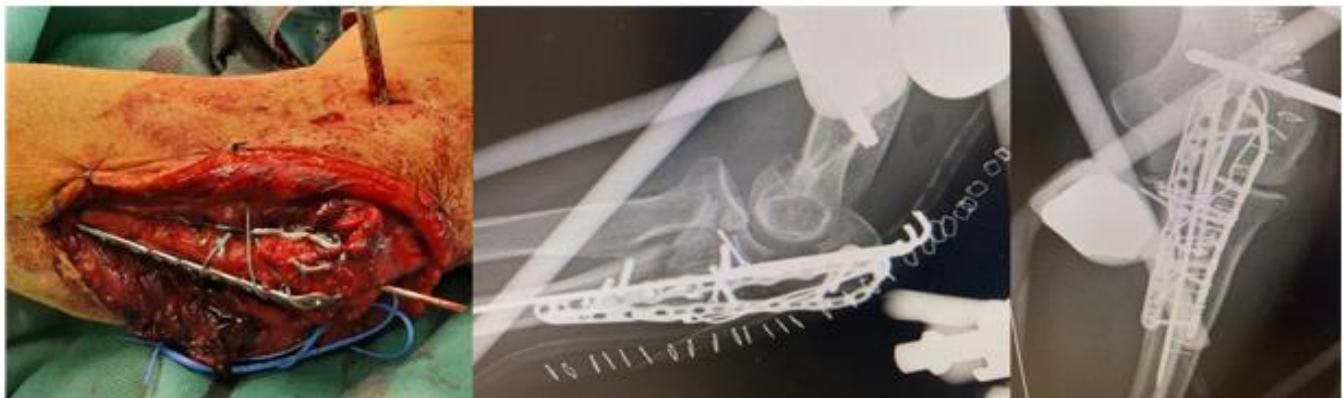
Case 2 - Intraoperative reduction-fixation and post-operative lateral and anteroposterior radiographs
